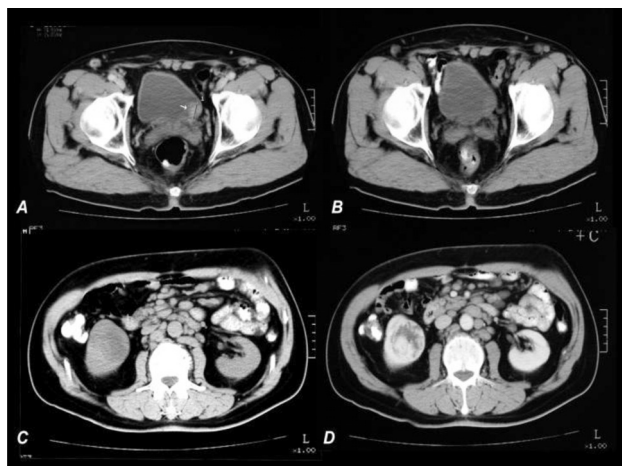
Computed tomography of the abdomen and pelvis: A – tumor in the urinary bladder with contrast applied (arrow), B – the same tumor without contrast; C – renal tumor without and D – with contrast applied.
